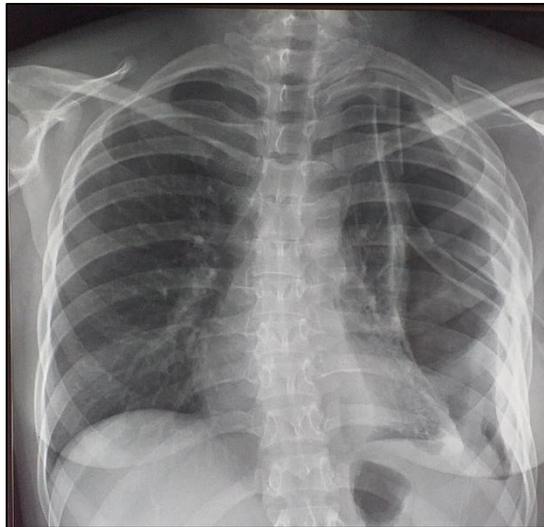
Postoperative thoracic radiograph showing persistence of left pneumothorax
